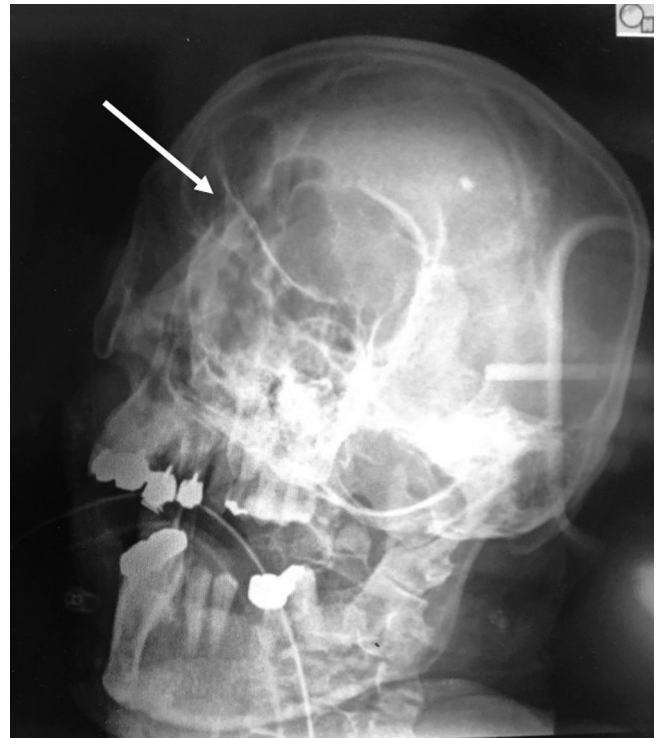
A portable cranial X-ray image of the present case. The X-ray showed left orbital fracture (arrow).
